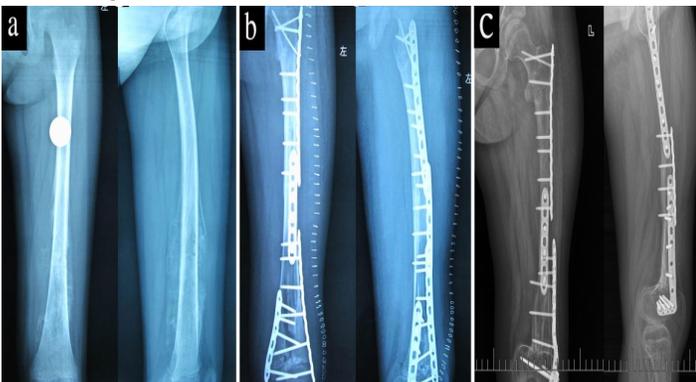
Radiographs of the involved femur ① before, ② after, ③ 38 months after the operation. Anatomical reduction and strong fixation of the femur bone are observed.
